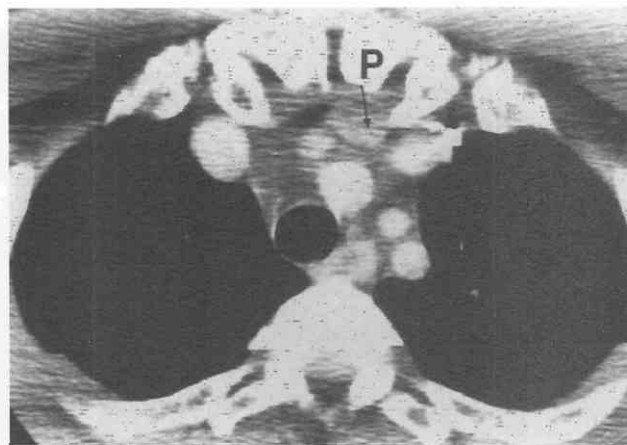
Ectopic parathyroid adenoma. CT shows a soft tissue mass in a patient who had undergone neck dissection for hyperparathyroidism with persistently elevated serum calcium. The parathyroid gland (P) is ectopic, located posterior to manubrium.
